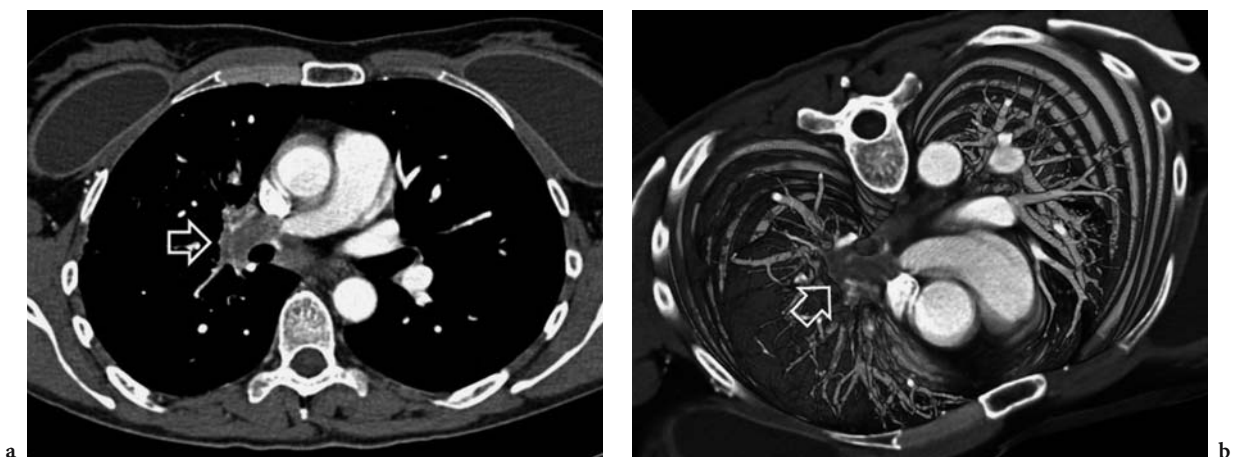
Multidetector-row CT angiography performed in a 52-year-old woman with dyspnea. Axial sections obtained at the level of the main pulmonary artery (a) show an endoluminal filling defect in the right pulmonary artery which was initially felt to be consistent with chronic thromboembolic changes. Surgical exploration after failure of specific treatment established a diagnosis of pulmonary artery sarcoma. A 3D volume rendering of the MDCT data set (b) may be better suited for appreciating the mass-like nature of the right pulmonary artery lesion
